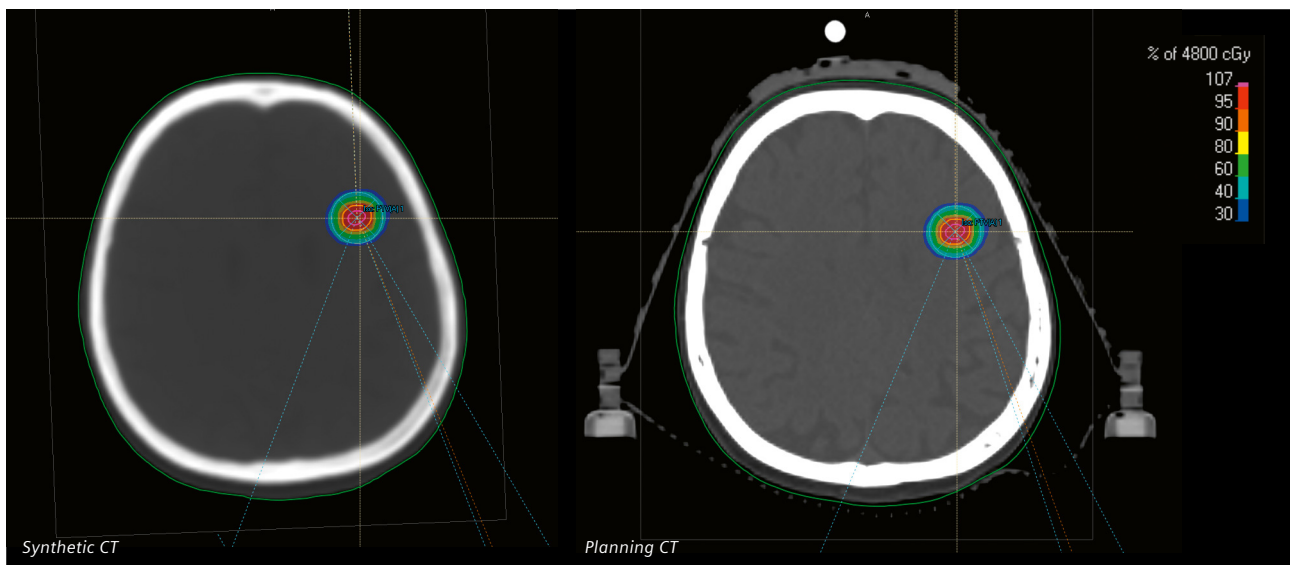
Dose distribution on Synthetic CT and CT with corresponding DVHs
